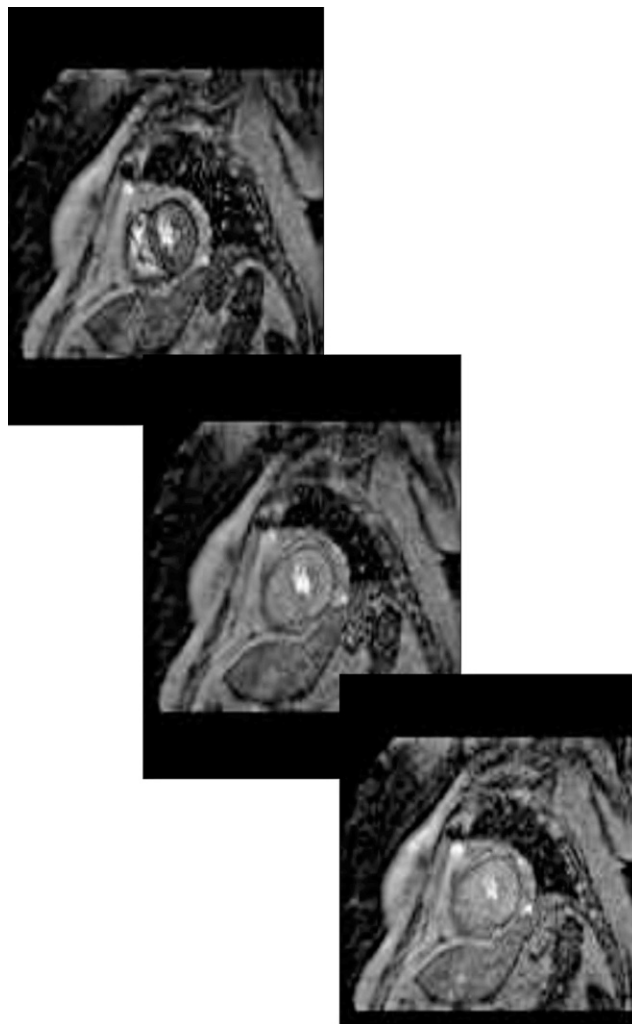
Case: 65-year-old male with history of recurrent lymphoma and coronary artery disease with newly depressed left ventricular function. Cardiac magnetic resonance imaging: Assessment of differential perfusion of the myocardium with gadolinium during adenosine stress. Diagnosis: Left ventricular ejection fraction, 41%. No evidence of ischemia.
